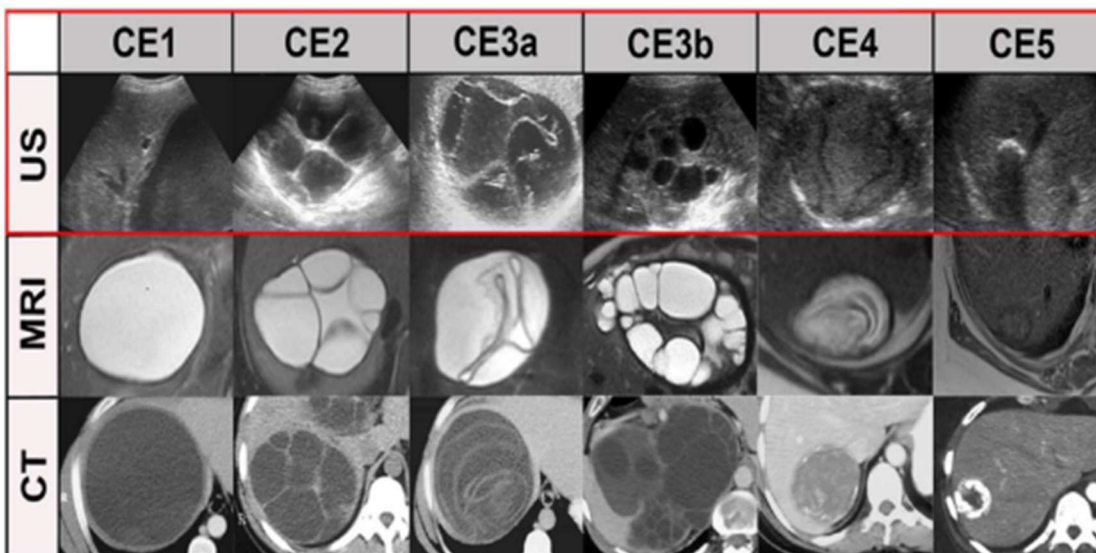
“Best case” of CT/MR imaging. CE1: unilocular, simple cysts with liquid content and often with the CE1-specific “double line sign”, CE2: multivesicular, multiseptated cysts, CE3a: cysts with liquid content and the CE3a-specific detached endocyst, CE3b: unilocular cysts with daughter cysts inside a mucinous or solid cyst matrix, CE4: heterogenous solid cysts with degenerative, CE4-specific canaliculated structure of the cyst content, and CE5: cysts with degenerative content and heavily calcified wall.
